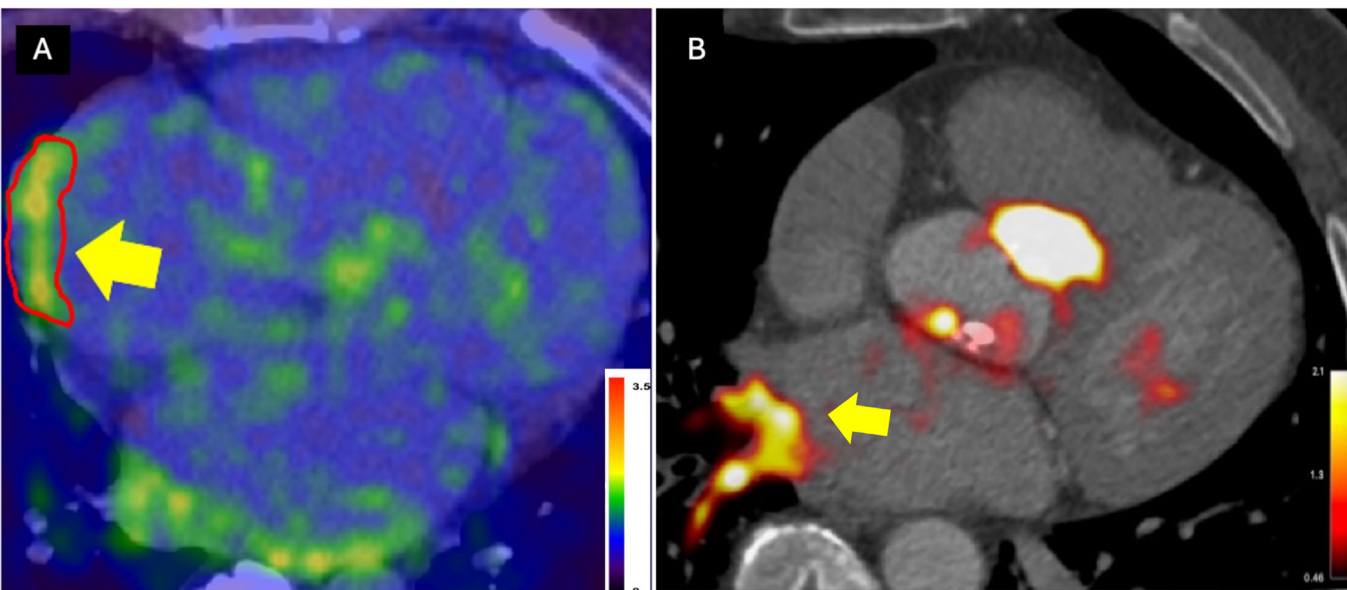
FAPI uptake in atrial fibrillation. A: An example of increased ^{18}F -AlF-FAPI uptake in the right atrial wall (TBRmax 2.5) in a fused PET-CT. Adapted from research originally published in JNC. Li et al. Li, Lina et al. fibroblast activation protein imaging in atrial fibrillation: a proof-of-concept study. *J. Nucl. Cardiol.* 2023. 30(6); 2712-2720(90) ^{68}Ga -FAPI uptake at the ostium of the left inferior pulmonary vein (A) and posterior wall of the left atrium (B) in a patient who also demonstrates ^{68}Ga -FAPI in their stenotic aortic valve. FAPI, fibroblast activation protein inhibitors; PET, positron emission tomography; CT, computed tomography.
